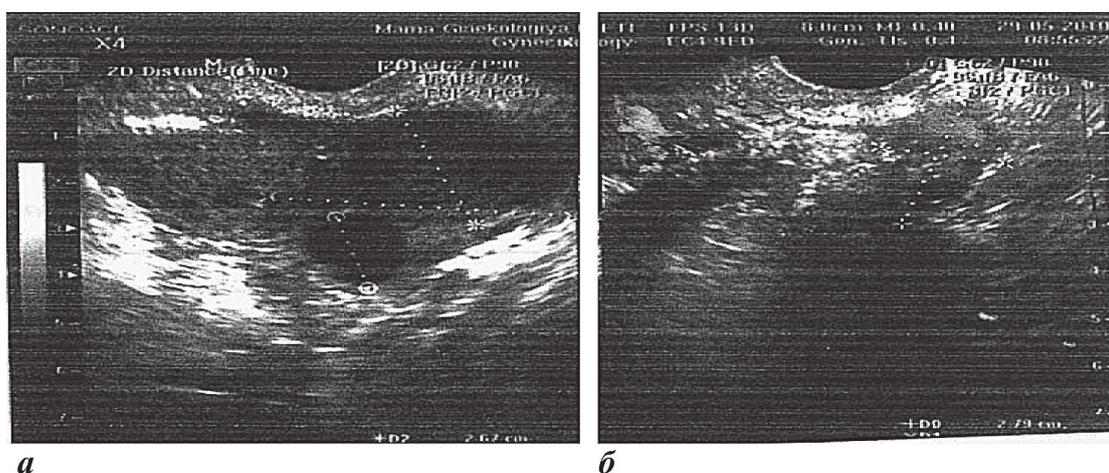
(a; b) – Ultrasound. Dense tumor in a patient with endometriosis (own observation)
